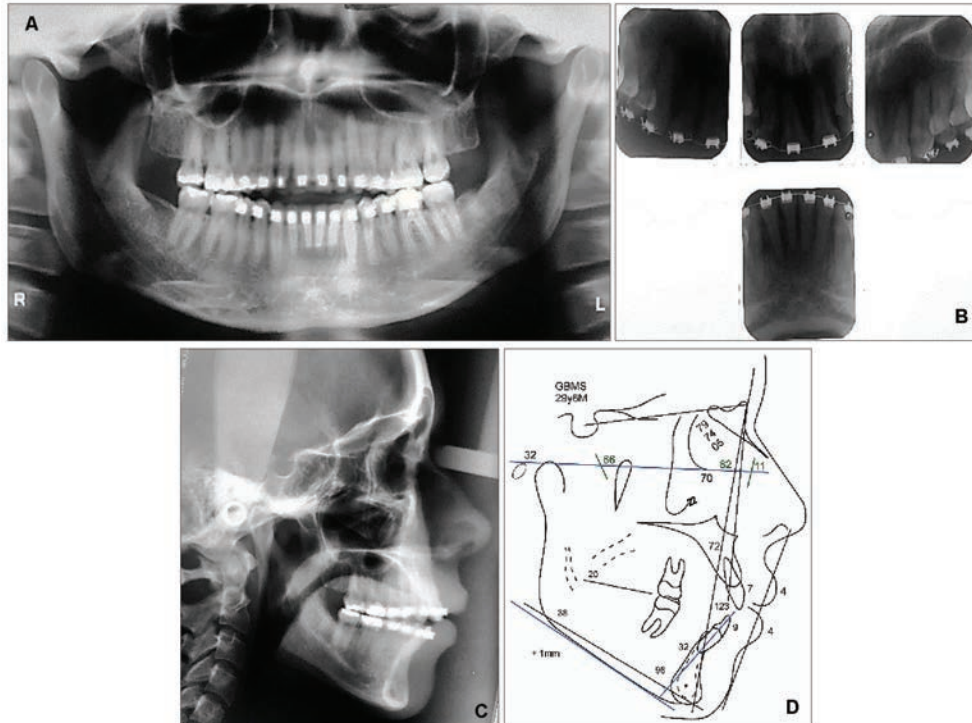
Initial X-rays (A-C). Periapical X-rays brought by the patient, with orthodontic wires (B). Initial cephalometric tracing (D).
